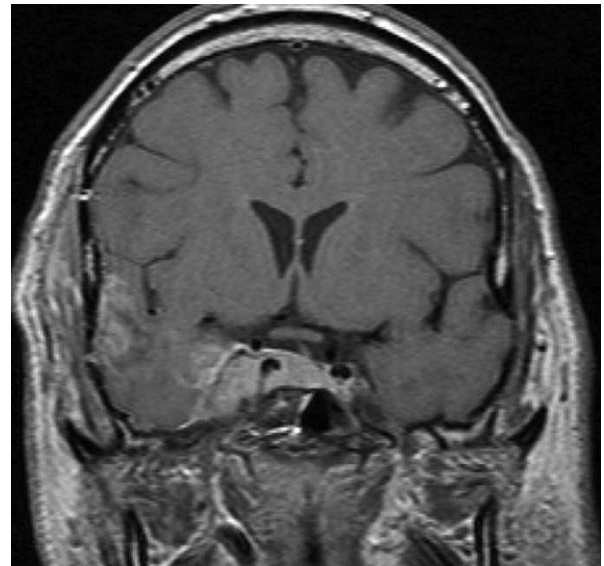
Coronal, T1-weighted, contrast-enhanced image demonstrating a homogeneously enhancing meningioma encasing the right internal carotid artery which is of normal calibre.
